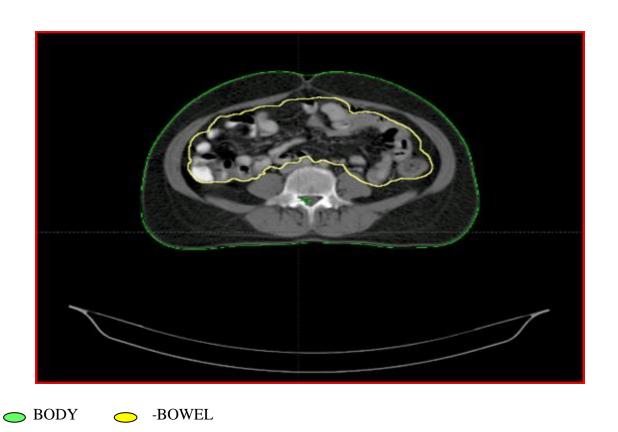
Delineation of bowel bag on CT scan
